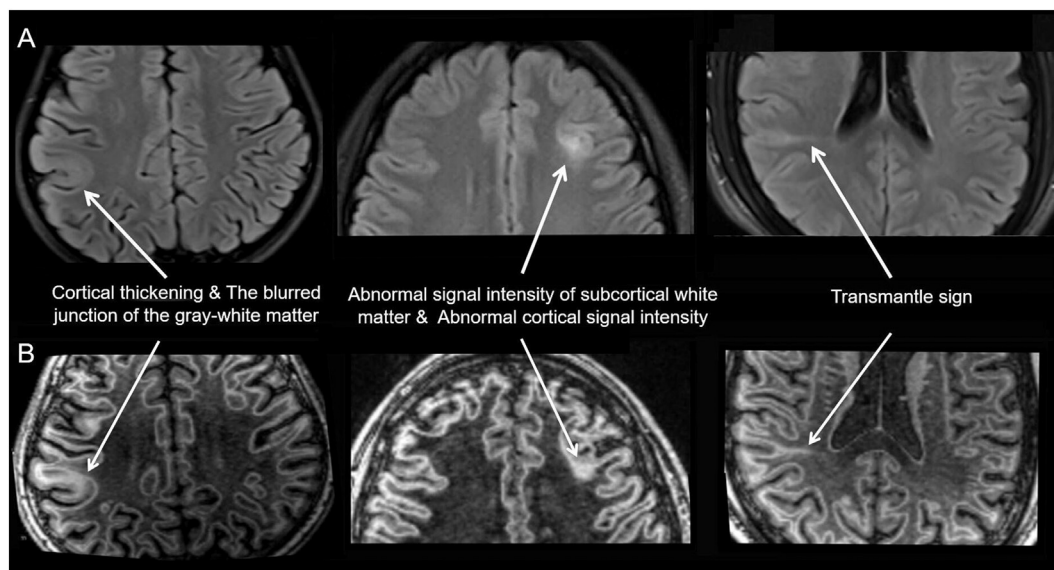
Sample graphs of five FCD features on the 2D axial FLAIR (A) and the FLAWS contrast image (B).
